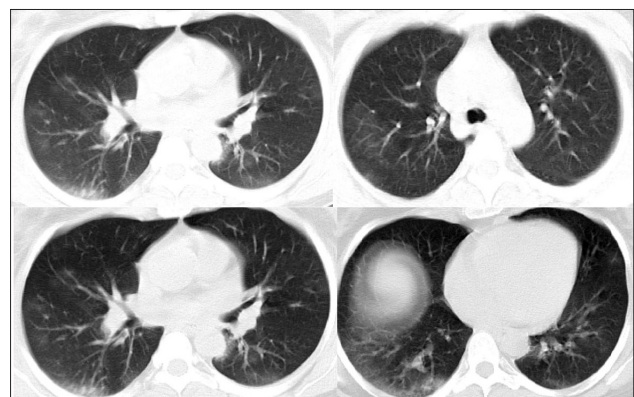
Thorax CT shows ground-glass opacities in the bilateral basal regions
